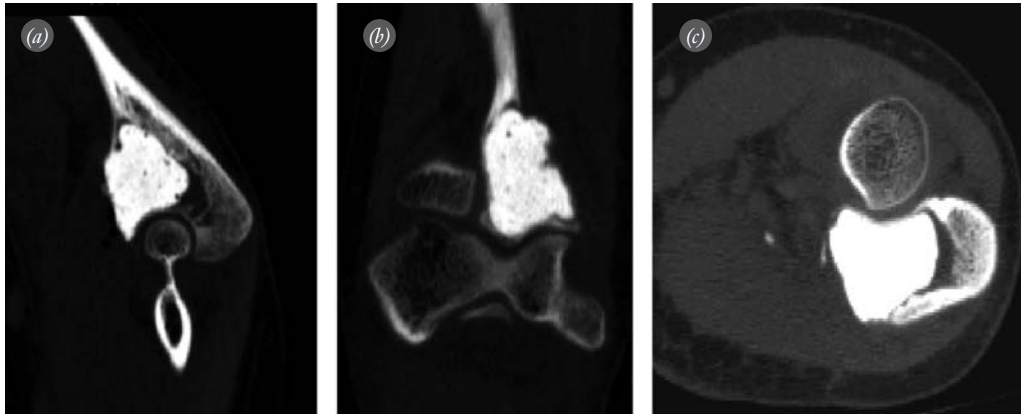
(a-c) Postoperative CT views showing the intact joint surface.
